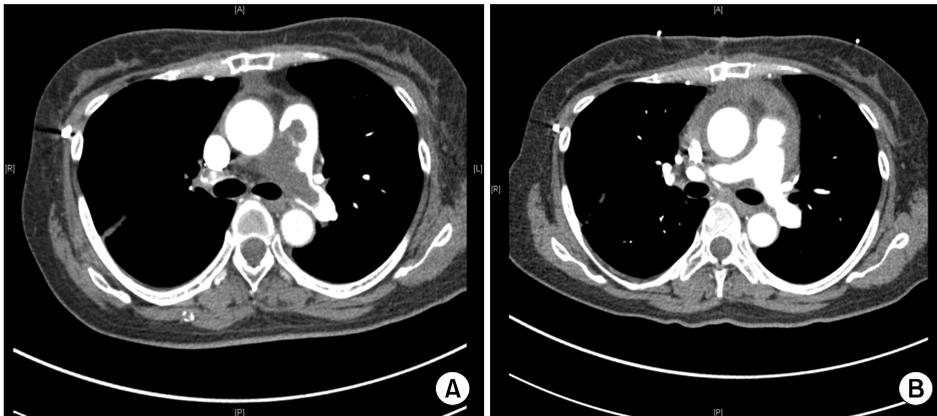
(A) Preoperative computed tomography: Leiomyosarcoma in the main pulmonary artery and right pulmonary artery. (B) Postoperative computed tomography: no cardiac mass in the main pulmonary artery and right pulmonary artery.
